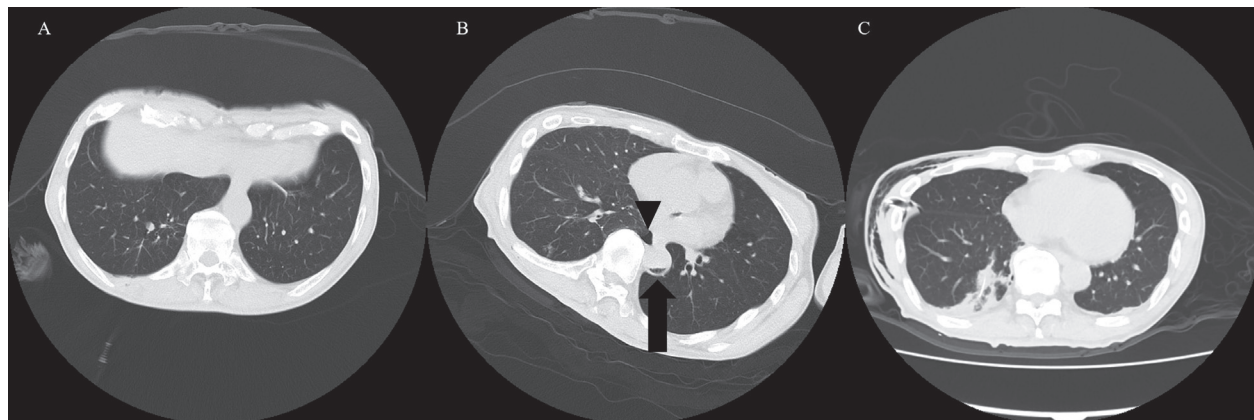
(A) A hook-wire was deployed at the RLL lesion under CT scan guidance. (B) Free air accumulation within the thoracic aorta (arrow) and right-side minimal pneumothorax (arrowhead). (C) CT scan revealed no free air within the cardiovascular system after HBOT. Chest tube insertion for right-side pneumothorax and a hook-wire at the RLL lesion.
